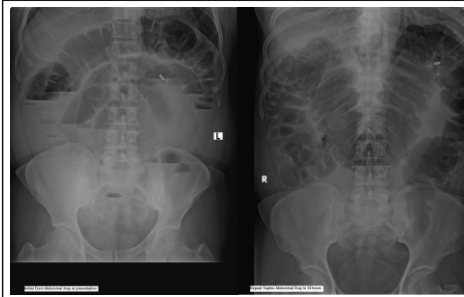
Abdominal X-ray features at presentation (left) and at 24 hours (right)
